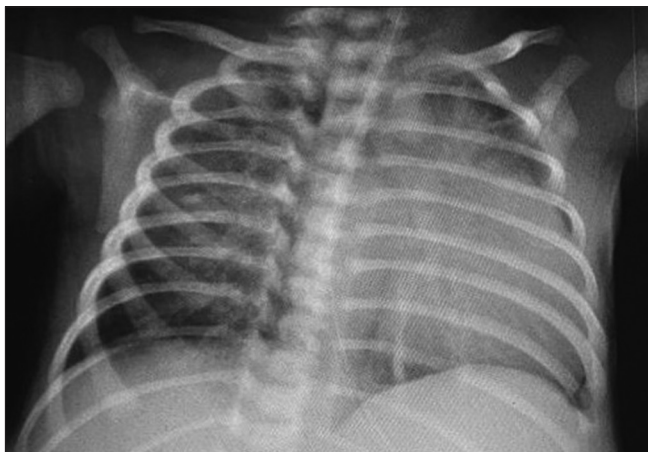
Chest X-ray on day 1 showing cardiomegaly (cardiothoracic ratio of 0.8)
